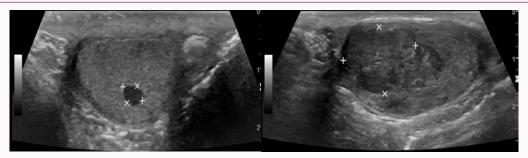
Scrotal ultrasound showing medial longitudinal view of the left testicle showing 0.48 x 0.37cm hypoechoic mass (left) and right testicle showing heterogeneous testicular mass (right).
